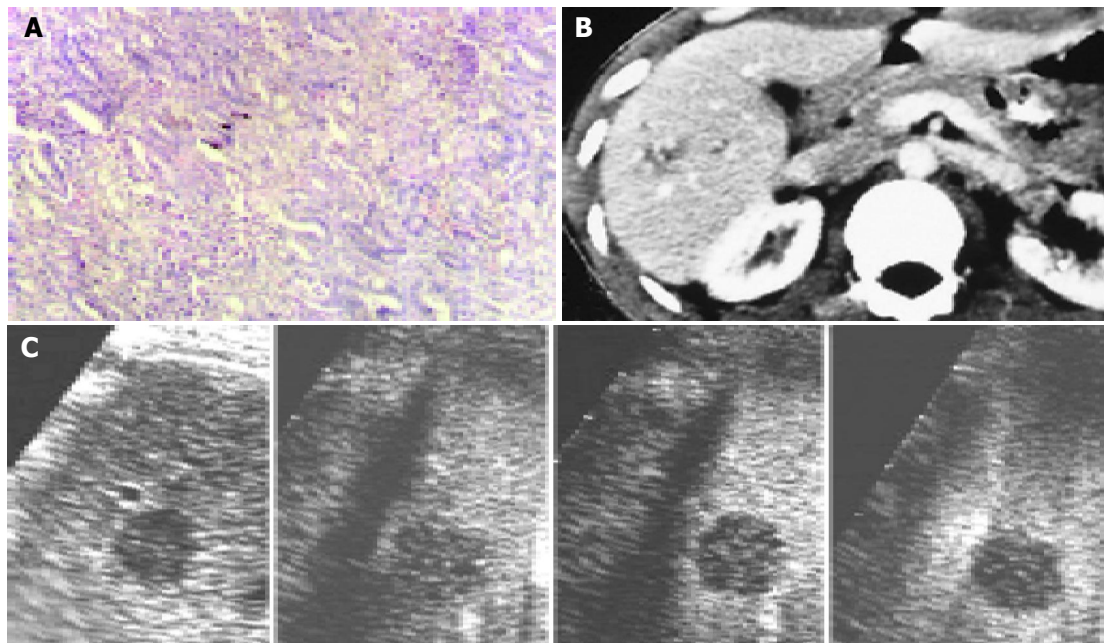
A: a 1.5 cm-sized metastatic adenocarcinoma in liver; B: low attenuation on contrast-enhanced CT; C: rim-like enhancement in early arterial
